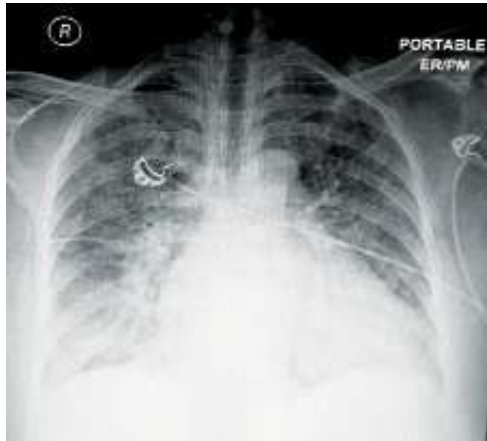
X-ray of the chest taken shortly before electrical cardioversion.
